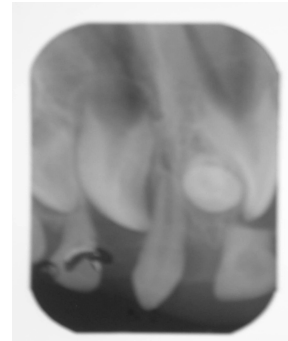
An intra oral periapical radiograph showing vertically impacted supernumerary tooth situated above the maxillary left deciduous central incisor.
